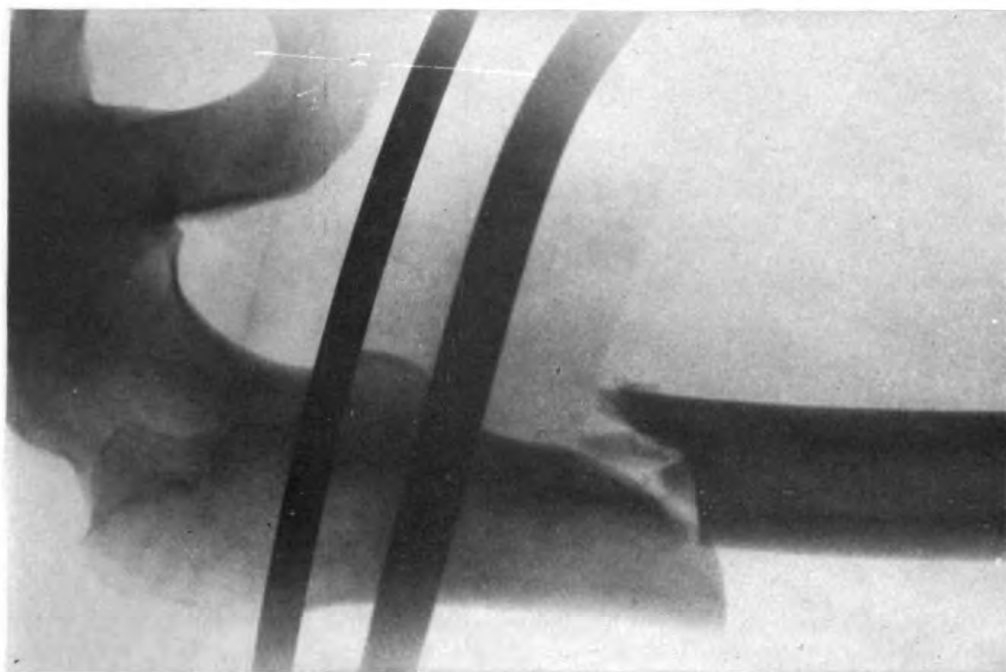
Case 3. Preoperative anterior-posterior x-ray.
